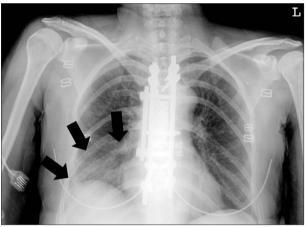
Plain chest X-ray obtained on admission day. Mild haziness is shown on the right lower lung field (black arrows). Note the installed metallic devices during the prior operation on the thoracic spine.
